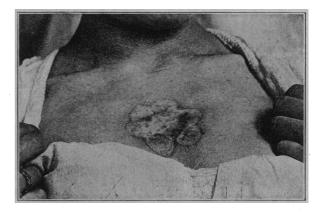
(Case 2).—Scars resulting from application of solid carbon dioxid following roentgen-ray treatment for keloid.
